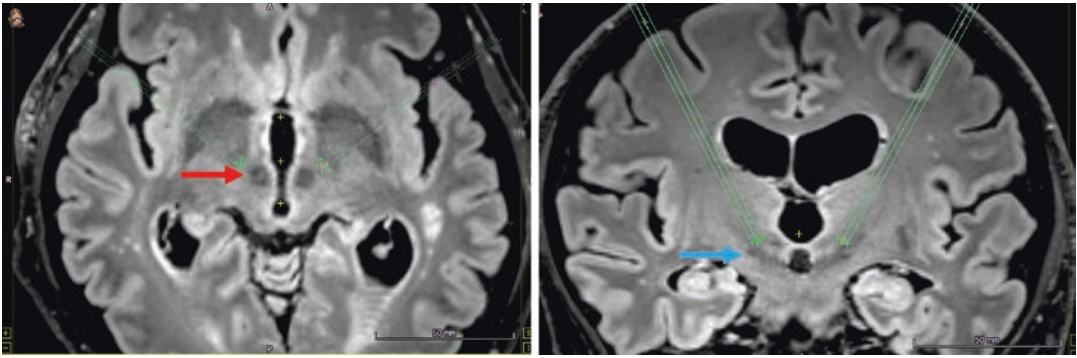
MRI-based targeting of the subthalamic nucleus. The subthalamic nucleus can be directly visualized using T2-weighted MRI for deep brain stimulation surgery. In this case, a FLAIR image shows the red nucleus (left panel, red arrow), which serves as an internal fiducial for
